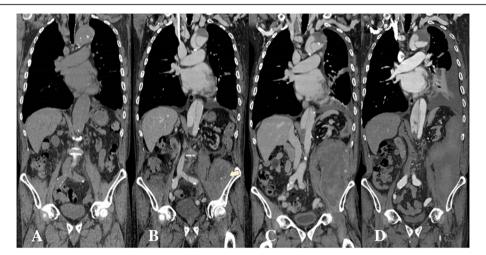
Abdominal computed tomography showed an iliopsoas hematoma. a Day 7, non-CECT revealed no obvious findings. b Day 8, CECT revealed an iliopsoas hematoma $(5 \times 3 \times 6 \text{ cm})$ with active contrast extravasation (arrow). c Day 24, CECT revealed an extremely enlarged hematoma $(10 \times 16 \times 8 \text{ cm})$. d Day 46, CECT revealed that the hematoma had stabilized and had not enlarged $(7 \times 20 \times 5 \text{ cm})$
